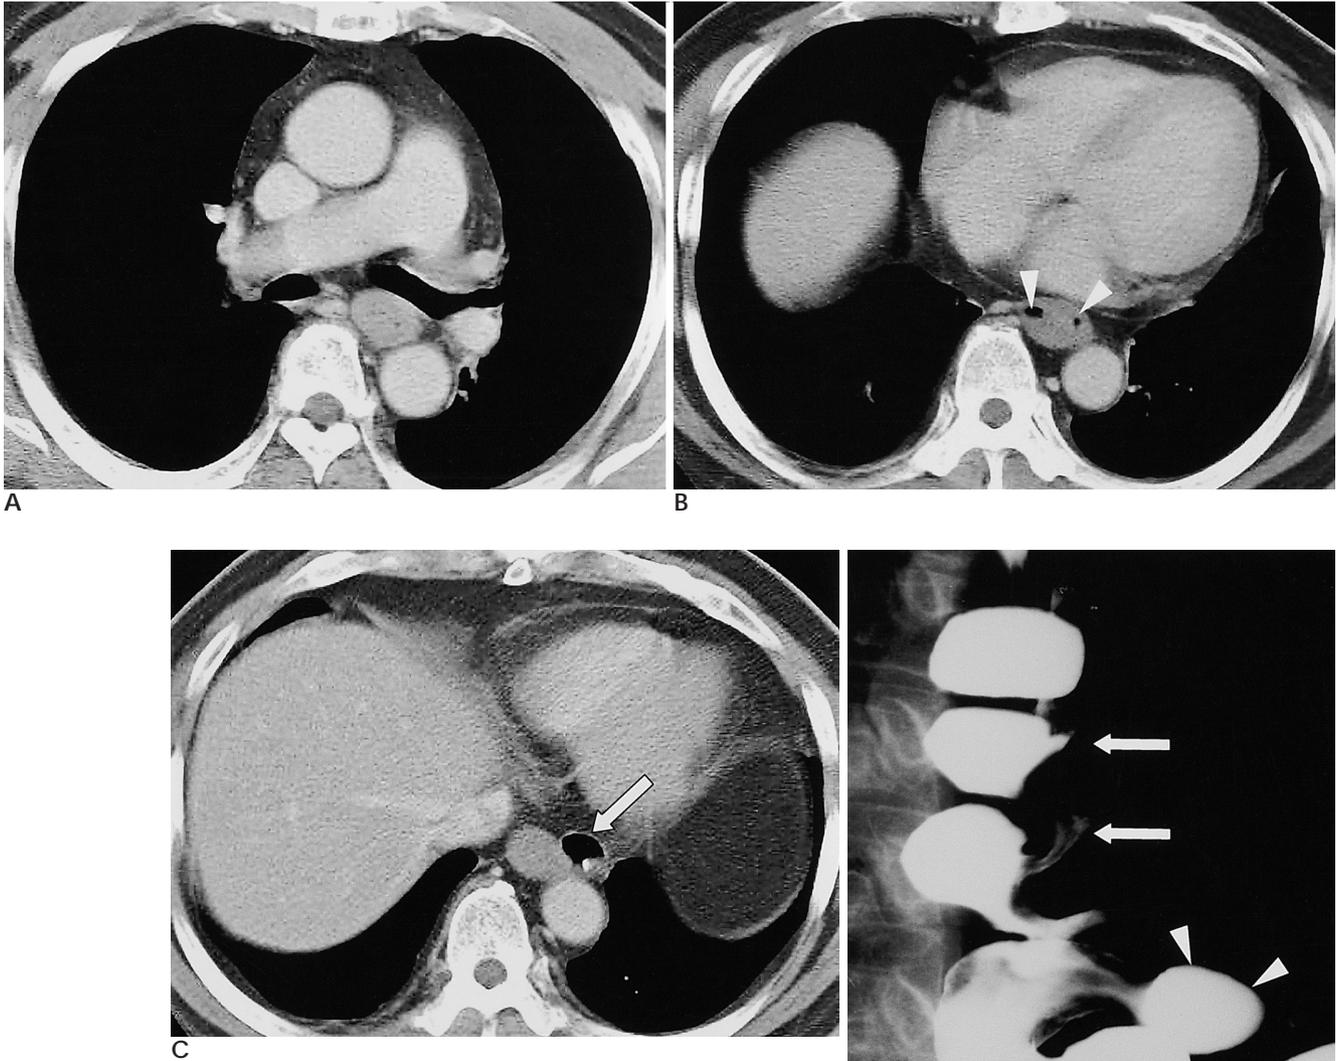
A. CT scan obtained at subcarinal level shows circumferential esophageal wall thickening with preservation of adjacent soft tissue plane. Dilatation of proximal esophagus was also noted (not shown). B. CT scan at hepatic dome level shows double intraluminal air densities (arrowheads), which is thought to be folding of the thickened esophageal wall. C. CT scan obtained at gastroesophageal junction level shows exophytic air density due to epiphrenic esophageal diverticulum (arrow). D. Double contrast esophagogram shows proximal dilatation and “cork screw” appearance due to prominent tertiary wave without mucosal abnormality (arrows). Also noted is epiphrenic diverticulum at gastroesophageal junction (arrowheads). Primary peristalsis was not seen on fluoroscopic evaluation after barium swallow (not shown).
